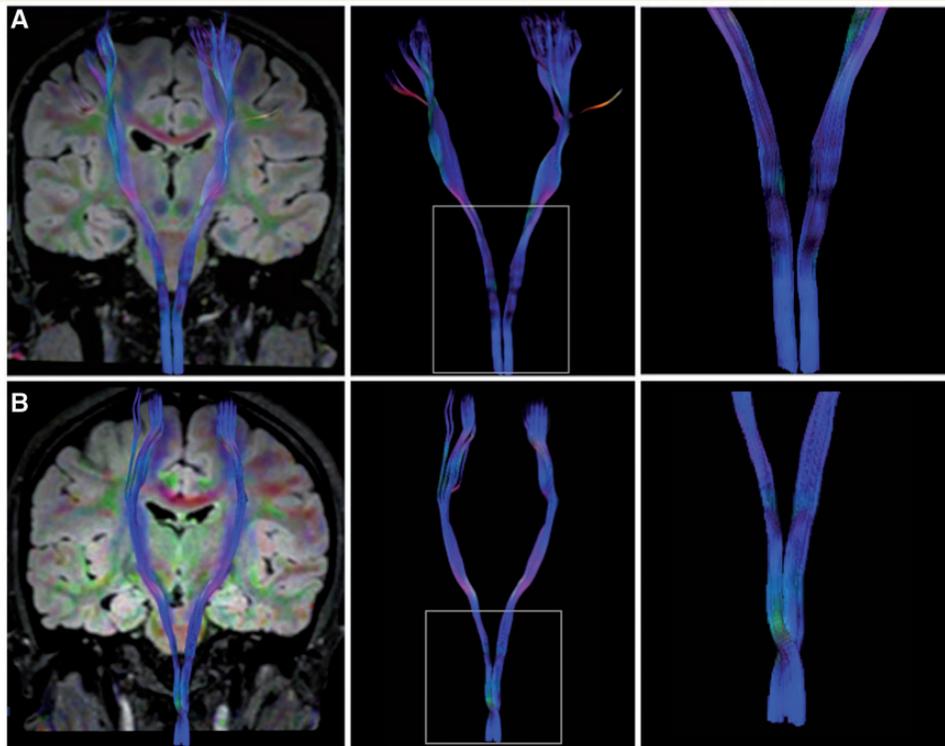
3.0 T MRI DTI tractography, (A) missing decussation of pyramids, with strictly unilateral non-crossing corticospinal tracts, and (B) a control subject, with normal crossing corticospinal tracts.
